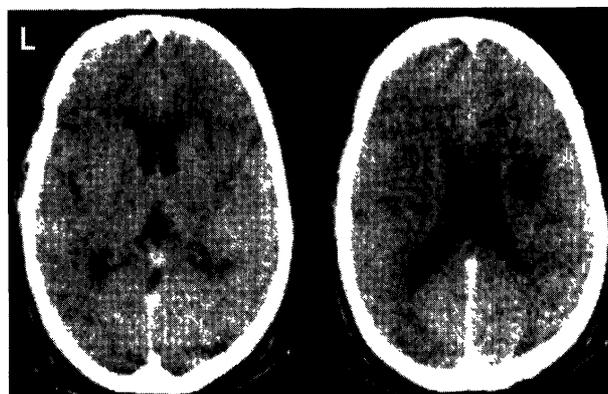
Precontrast CT scan on admission showing low-density lesions in the right basal ganglia and centrum semiovale.
